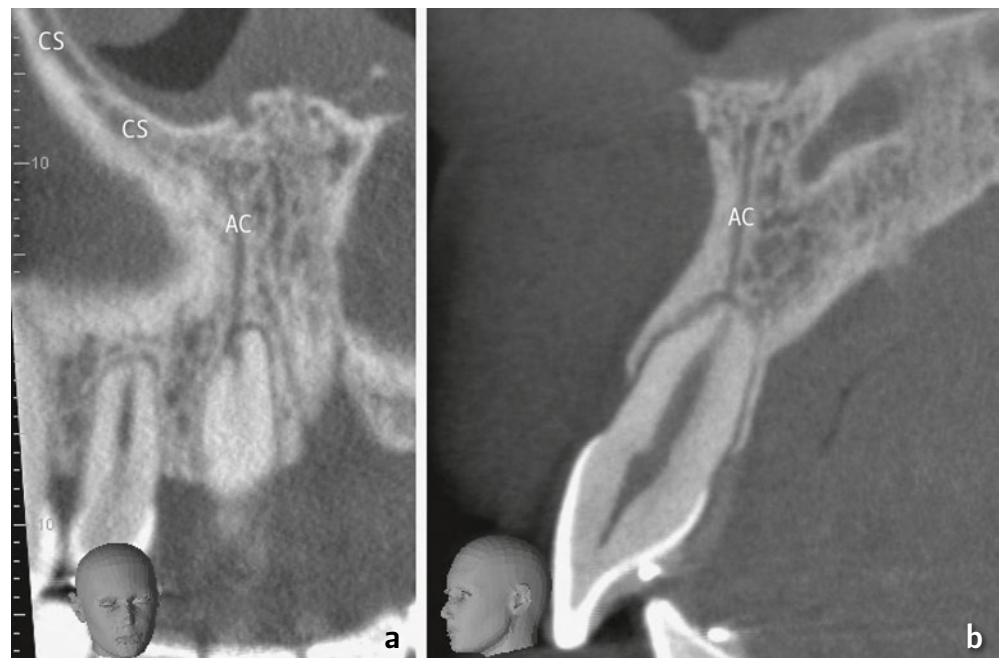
Coronal (a) and sagittal (b) reformatted CBCT images of a 22-year old male showing AC (originating from CS) supplying the right central maxillary incisor.
